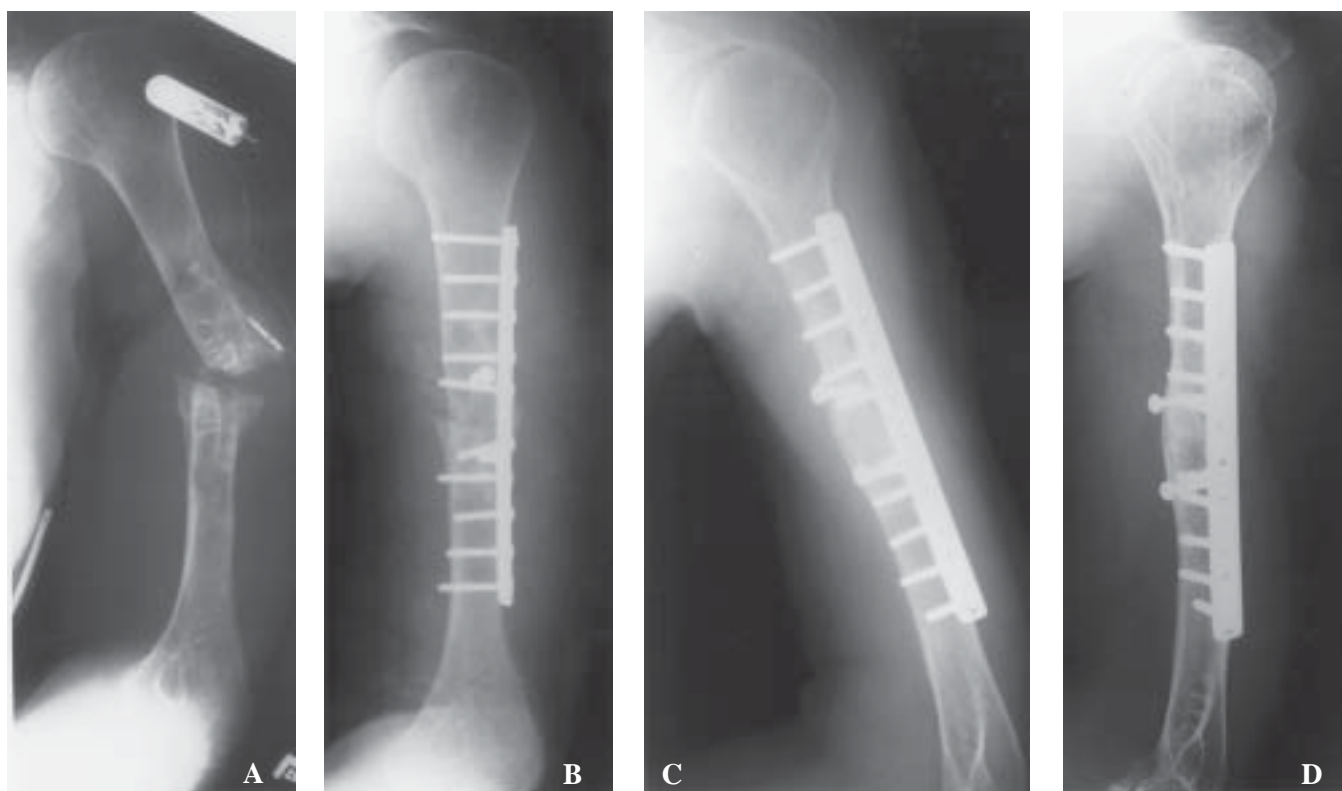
(A) Preoperative roentgenogram (7/27/83). Primary treatment was hanging arm cast for one year. Secondary treatment was ORIF and tertiary treatment was electrical stimulation. (B) Immediate post-operative roentgenogram (7/28/83). Iliac crest bone graft is applied 90 degrees from the compression plate. (C) Six month post-operative roentgenogram (12/23/83). Healed nonunion after treatment with dynamic compression plating and rigidly fixed tricortical bone grafting. (D) Most recent roentgenogram (6/19/96). Humerus remains solid clinically and radiographically.
